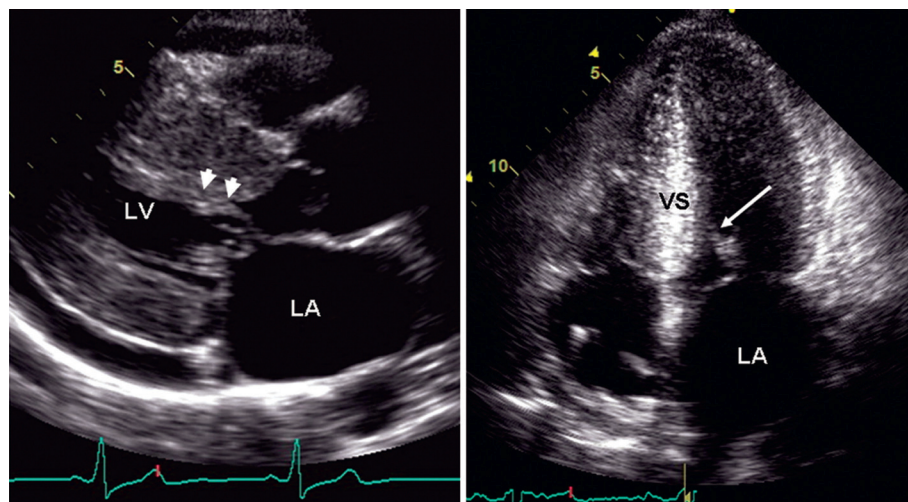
HCM. A parasternal long-axis view (left panel) shows markedly increased septal wall thickness and systolic anterior motion of the mitral valve (arrows), also visualized in the apical four-chamber view (right panel). Note the sigmoid, banana-shaped septum. LA = left atrium; LV = left ventricle; VS = interventricular septum.
